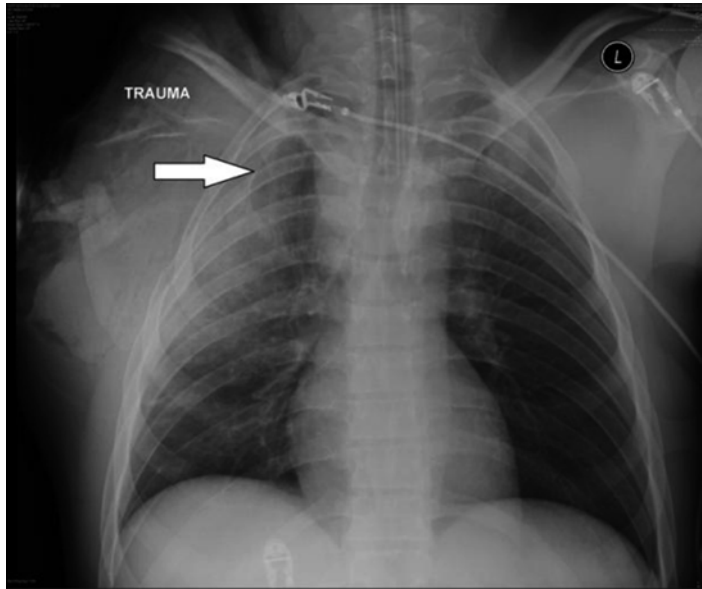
Radiograph of flail chest with underlying lung contusion (indicated by arrow)
